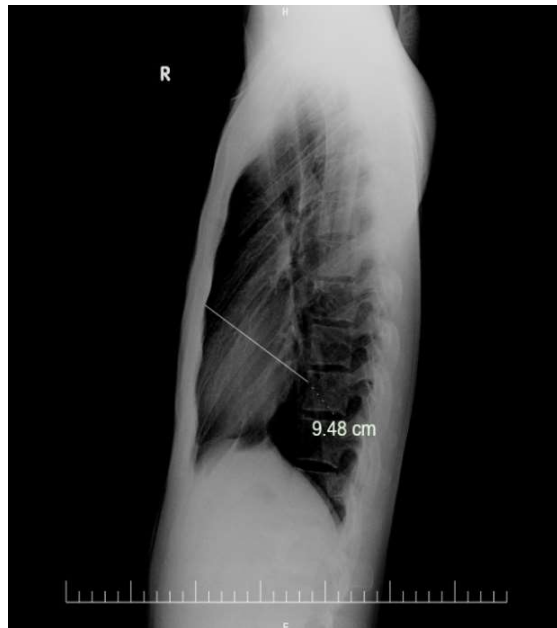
Chest Xray showed reduced anteroposterior length
